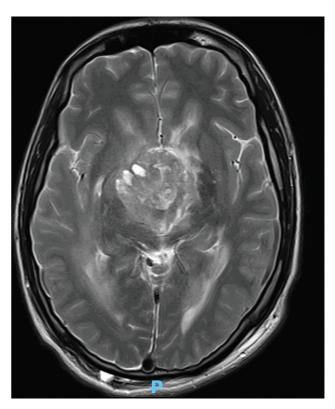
Glioblastoma: MRI exhibiting a solid-cystic lesion, which determined hydrocephalus, compression of the interpeduncular region of the midbrain, a reduction of perimesencephalic cisterns, and edema.
